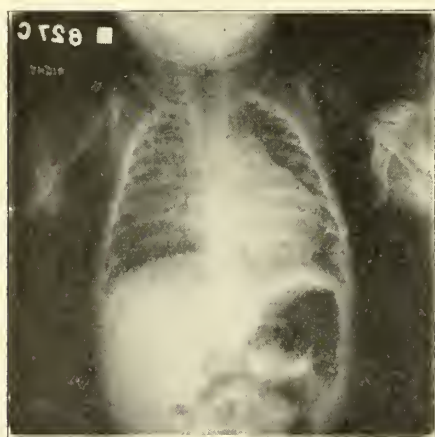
Roentgen ray of chest in Case 5. Enlarged wing-shaped thymic shadow and markedly enlarged heart.
